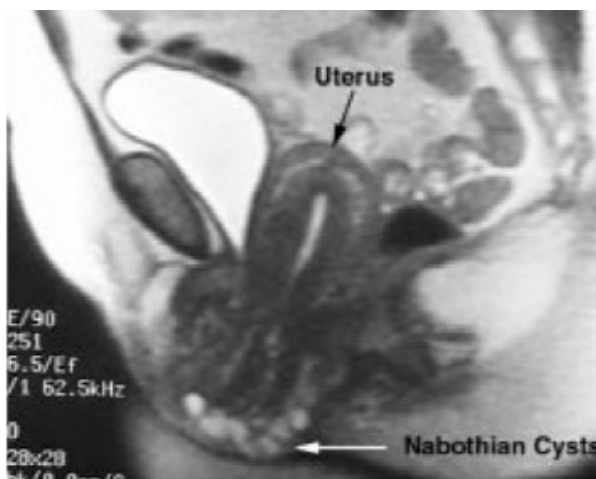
Pelvic Floor MRI: Uterine Prolapse
